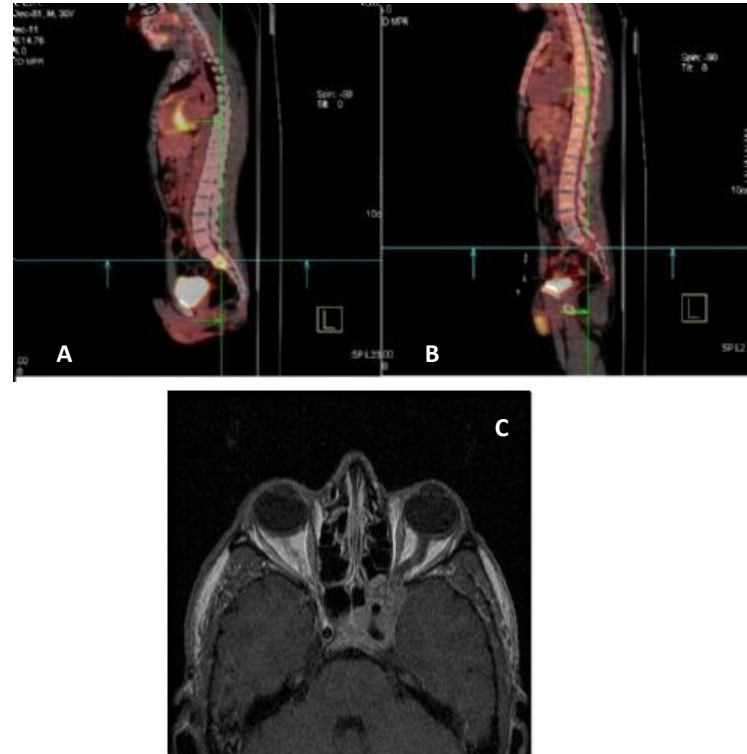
Pathological 18F-FDG uptake in the sacroiliac joint at time of diagnosis (a) and metabolic complete response after chemotherapy (b). Left retroorbital mass in orbital magnetic resonance T1-section imaging (c).
